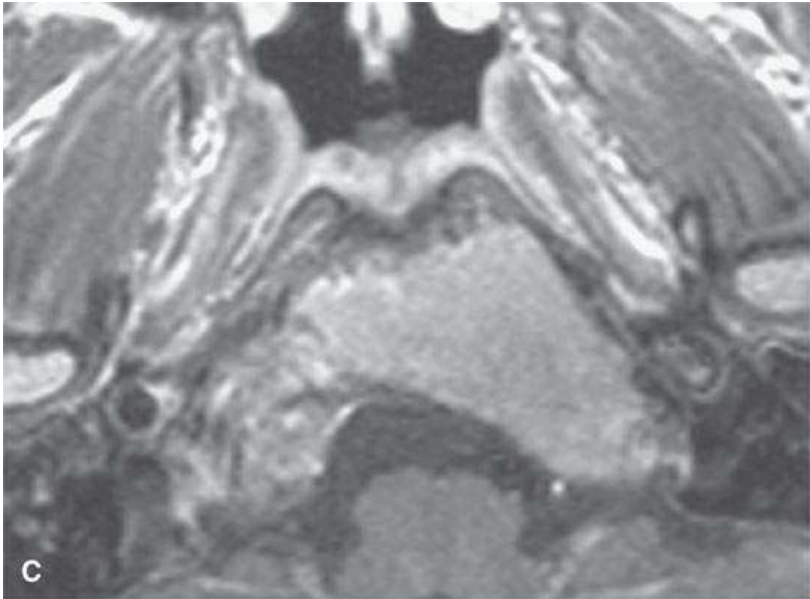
Fibrous dysplasia of the clivus can mimic more ominous process. A: T1-weighted non-contrast-enhanced image shows an “infiltrated”-appearing clivus. B: T2-weighted image supports an abnormal marrow space, C: T1-weighted contrast-enhanced image shows enhancement (compare with A). D: Non-contrast-enhanced computed tomography of a typical fibrous dysplasia, although one could think about an osteoblastic metastasis or lymphoma until the expanded appearance of the bone is fully appreciated.
